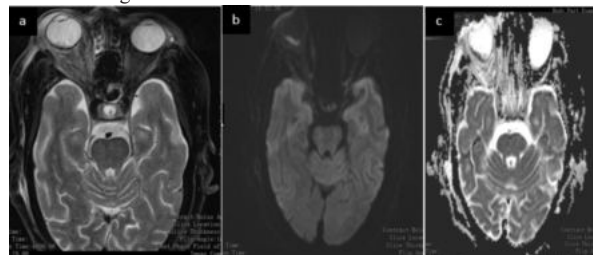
Complication of ROCM in a 52 year old patient with involvement of retinochoroid a) T2 axial shows extensive orbital involvement with subtle irregularity in globe on right side b) c) DWI shows diffusion restriction confirmed on ADC
